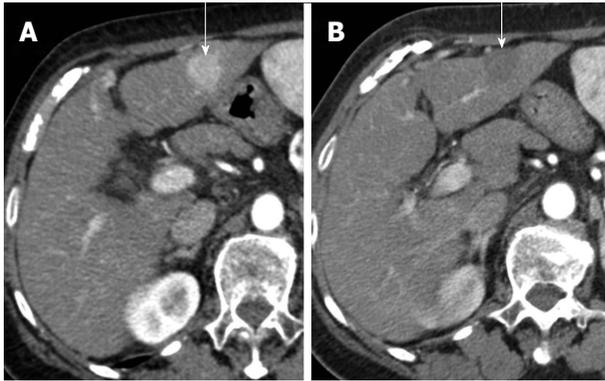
Complete necrosis after radiofrequency ablation for hepatocellular carcinoma. A: Pretreatment arterial phase computed tomography (CT) shows hypervascular hepatocellular carcinoma (arrow); B: Arterial phase CT obtained 1 mo after treatment shows ablated area (arrow). Absence of arterial enhancement suggests complete tumor necrosis.
